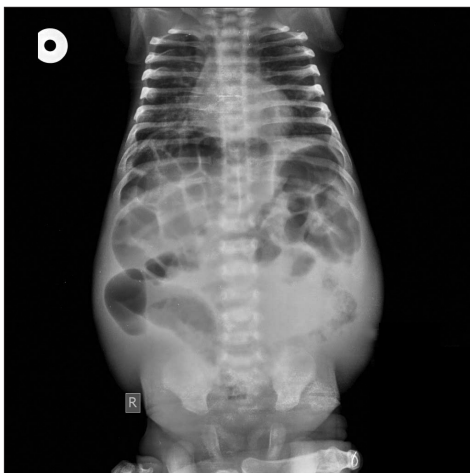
10 days male baby X-ray shows gas between under the diaphragm and liver
